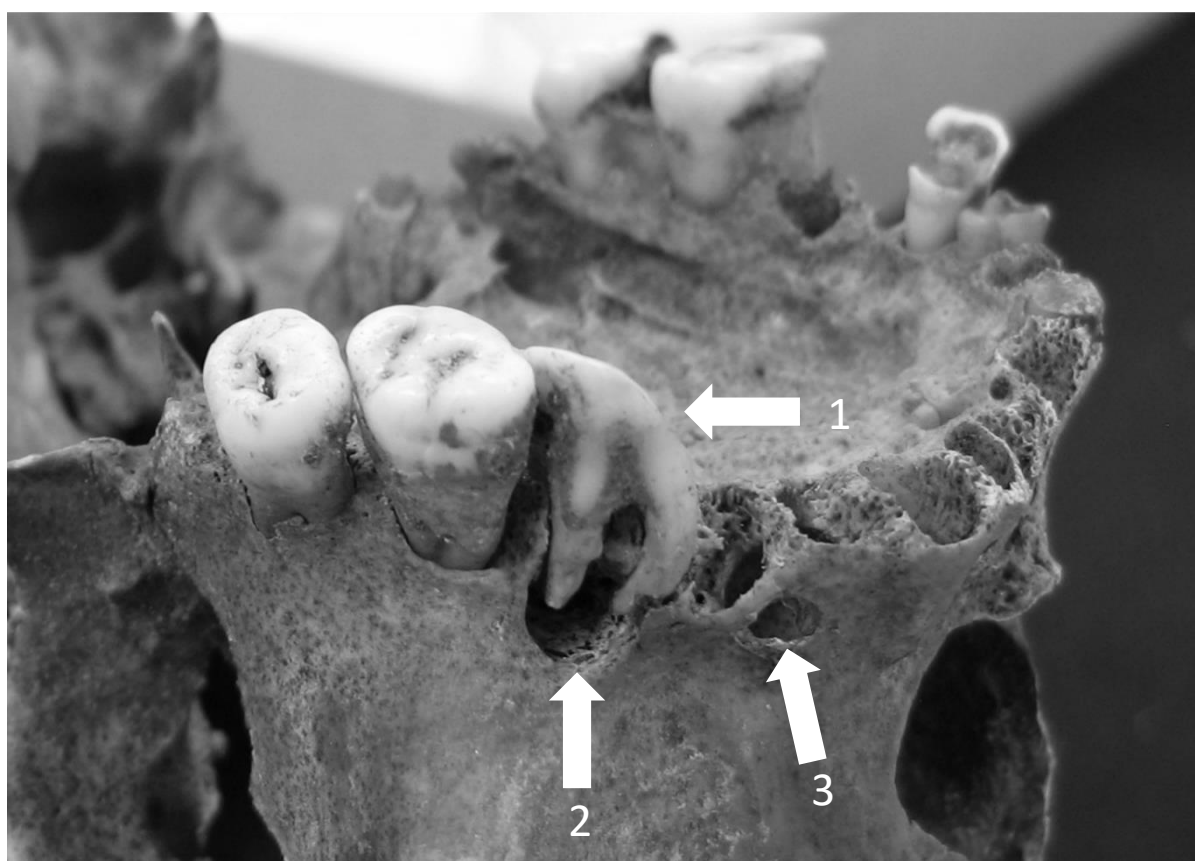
Severe attrition of the left upper M1 (1) and periapical lesions related to the same tooth (2), as well as both premolars (3), in a 30-40 years old male from MG2 (burial 469).
